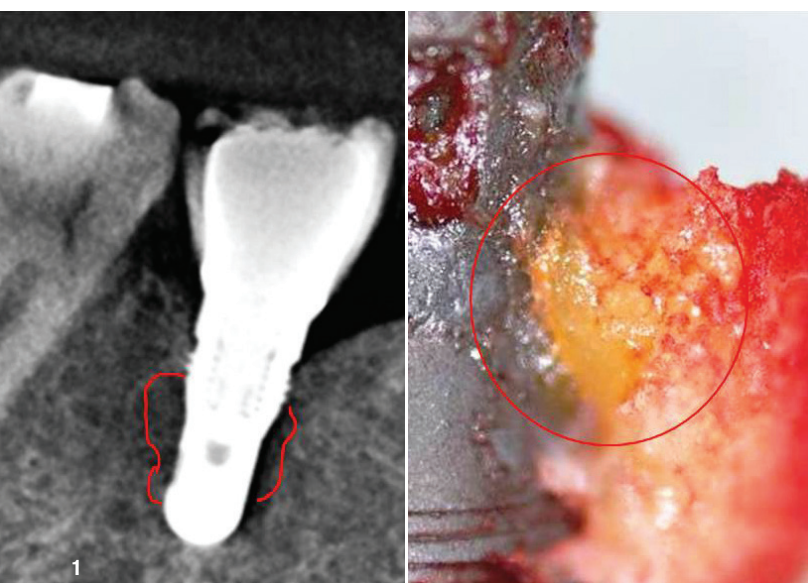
Titanium implant as shown in CBCT; fatty-degenerated FDOJ/BMDJ attached directly to the Ti-Impl.
